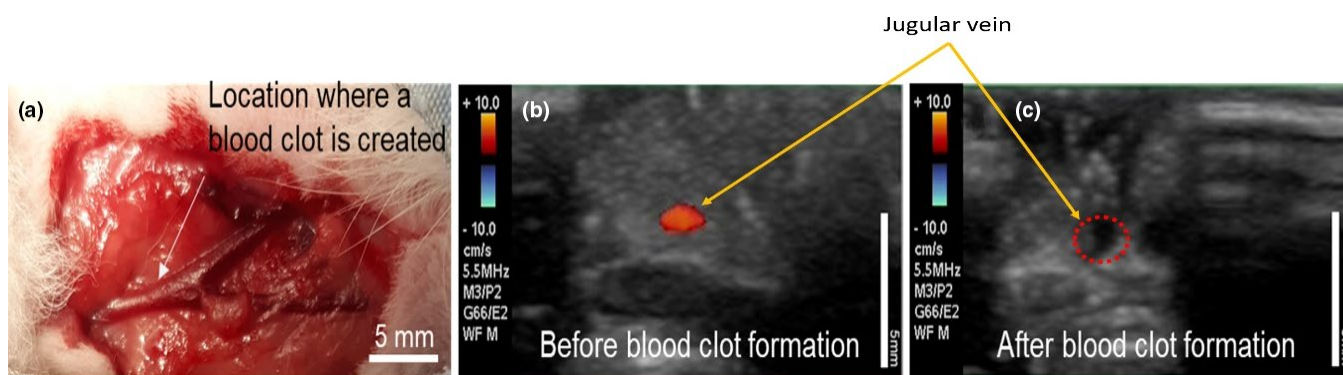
(a) Location of the blood clot in the isolated rabbit's right jugular vein. (b) Ultrasound Doppler imaging before formation of blood clot in jugular vein. (c) Ultrasound Doppler imaging after formation of blood clot in jugular vein
